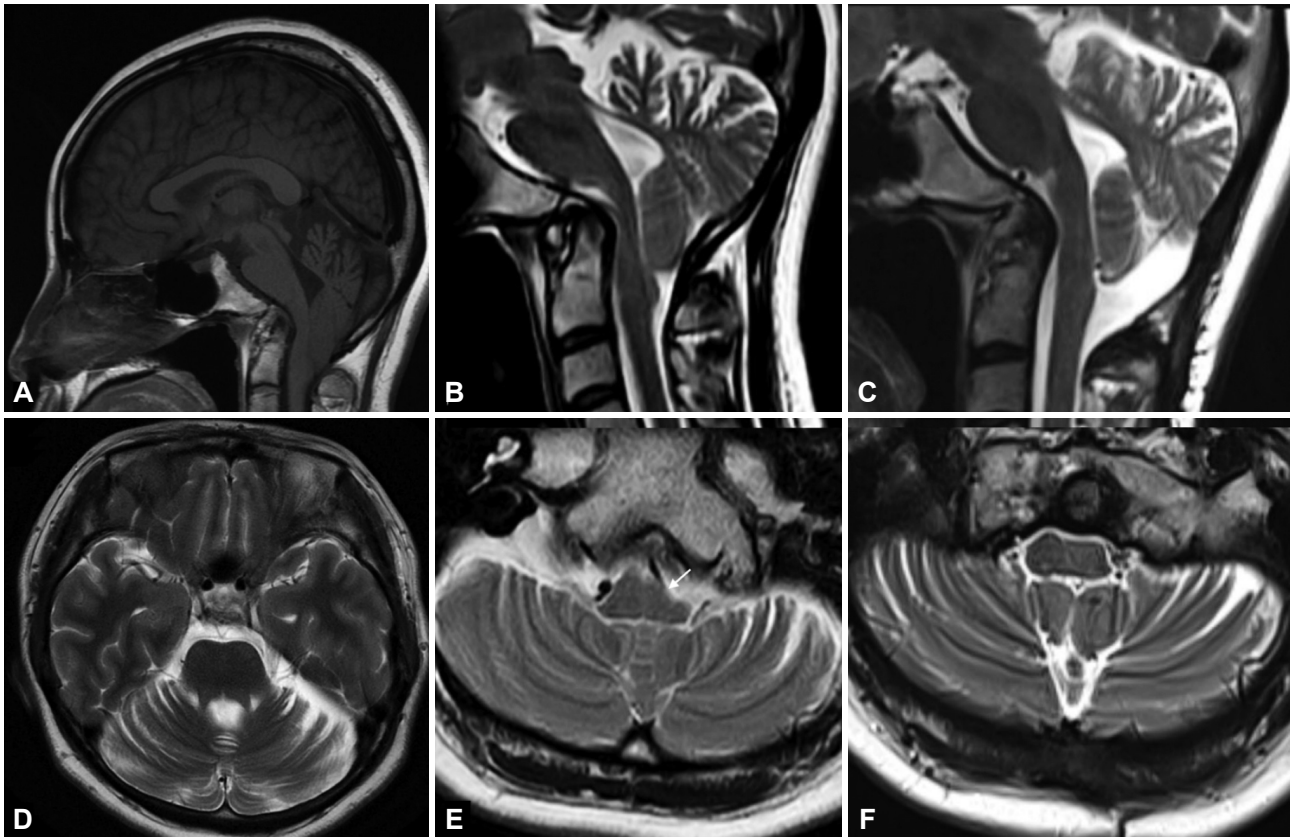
Radiological findings in the patient. A: Magnetic resonance imaging (MRI) of the brain and cervical spine showing complete atlanto-occipital assimilation with marked basilar invagination, platybasia, and cerebellar atrophy. B: MRI showing severe cerebellar atrophy associated with basilar invagination. C: MRI after surgery revealed good decompression. D: MRI showing severe bilateral cerebellar atrophy, especially in the affected vermis. E: The lower medulla is markedly compressed on the left dorsal surface (white arrow). No signs of brainstem or cerebellar infarction or cerebral cortical atrophy were observed. F: After decompression surgery, the compressed area of the left lower medulla also appeared to have improved.
